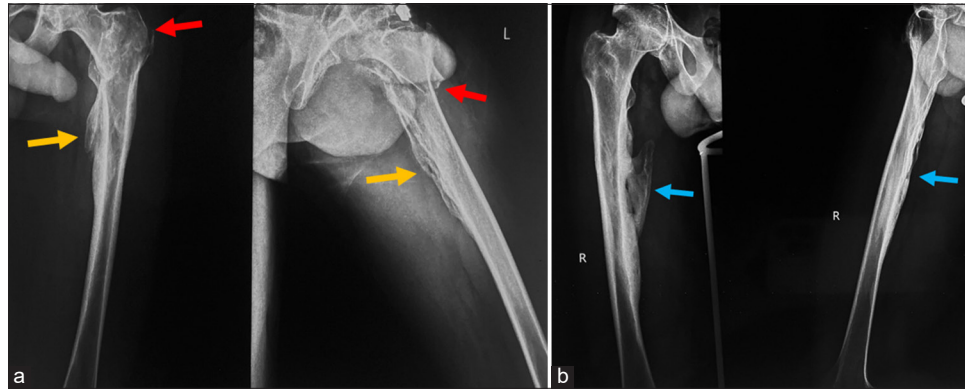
(a) Frontal and lateral radiographs of the left femur show healed old fracture of the proximal shaft with hyperplastic callus formation (orange arrows) and a displaced subtrochanteric fracture (red arrows). (b) Frontal and lateral radiographs of the right femur show healed old fracture of the midshaft with hyperplastic callus formation (blue arrows).
